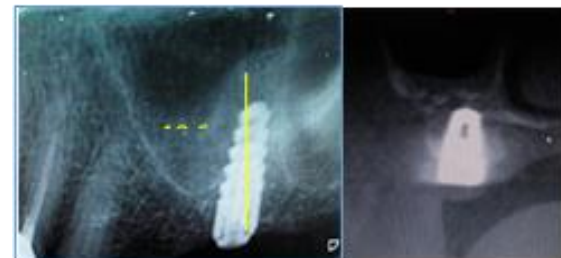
Post-op OPG and CT Scan (Indirect Sinus Lift).
